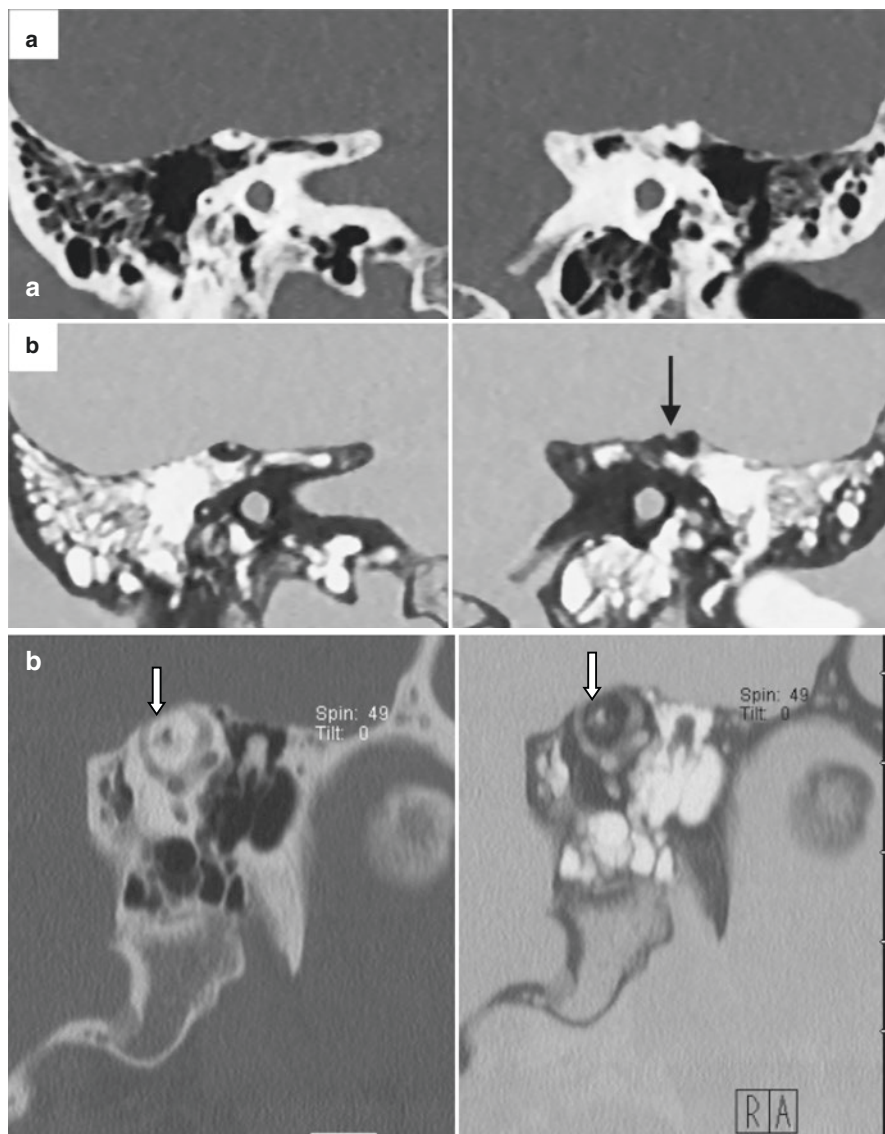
(a) SSCD on coronal CT scan: (a) standard images suggestive of bilateral SSCD and (b) invert function revealing thin bony covering over right superior semicircular canal and left dehiscence (arrow). (Reproduced with permission of *Annals of Otolaryngology, Rhinology & Laryngology* [8]). (b) Arrows point to SSCD on Pöschl View using standard images and invert function
